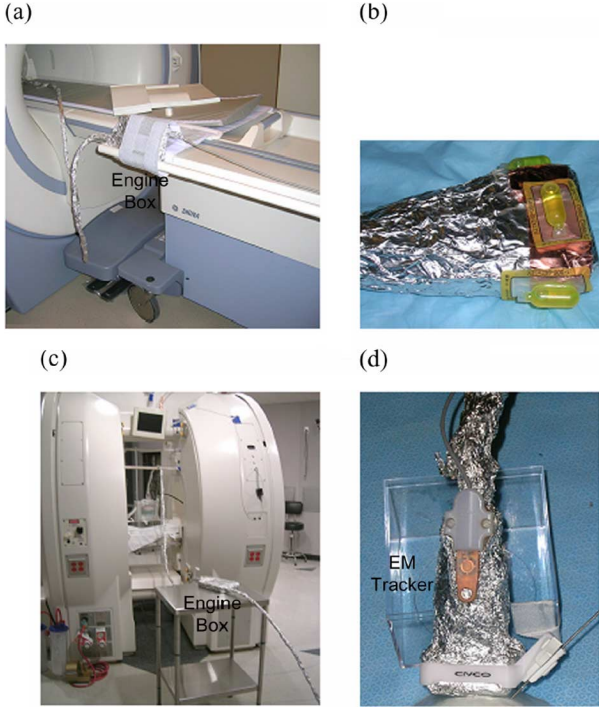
Experimental setup of simultaneous MR/US imaging. (a) Shielded US in 3 T close bore MRI system, (b) US transducer head with MR visible fiducial markers attached, (c) shielded US in 0.5 T open bore MRI system and firewire cable routed orthogonal to the bore through the vertical gap, and (d) US transducer head with EM tracker and needle guide attached.
